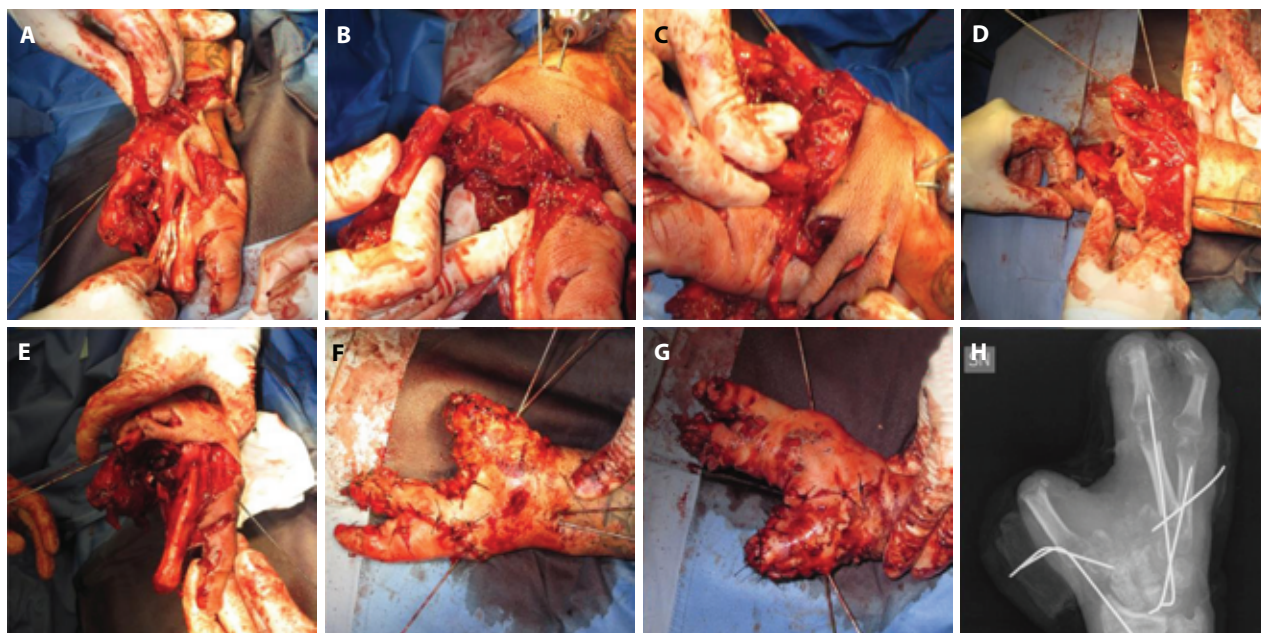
Reconstructive surgery. A: first ray stabilization (trapeze-metacarpal joint). B: the second metacarpal bone was harvested. C: the second metacarpal bone reconstructed the fourth ray (non-vascularized bone graft). D: osteosynthesis of the ulnar metacarpal bones. E: Final appearance before skin closure. F: Dorsal view. G: palmar view. H: post-operative X-ray.
